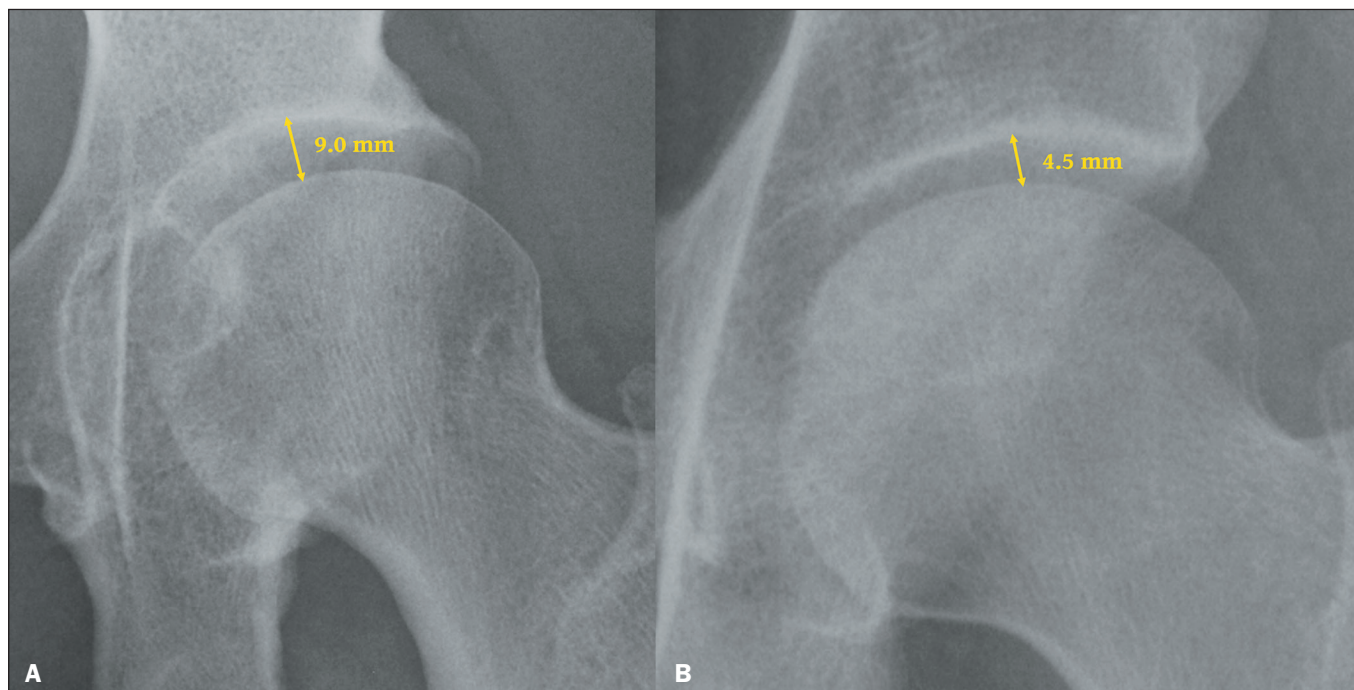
Radiograph of the left hip, in an anteroposterior view, showing an increase in the femoroacetabular joint space in a patient with acromegaly (A), compared with the normal space in a healthy patient (B).
